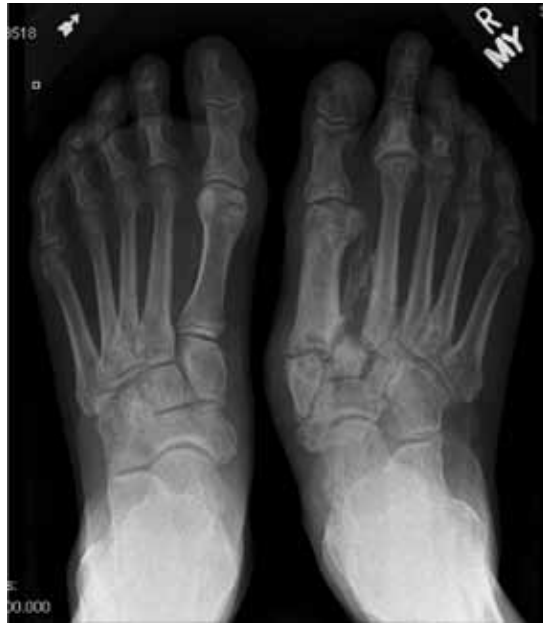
Stage 3. This plain radiograph shows the reconstruction stage with resolved edema, absence of osteosclerosis, and relative osteopenia. Also seen is healing of the fractures of the second and third proximal phalanges, the site of the ecchymosis on plain films in FIGURE 2.
